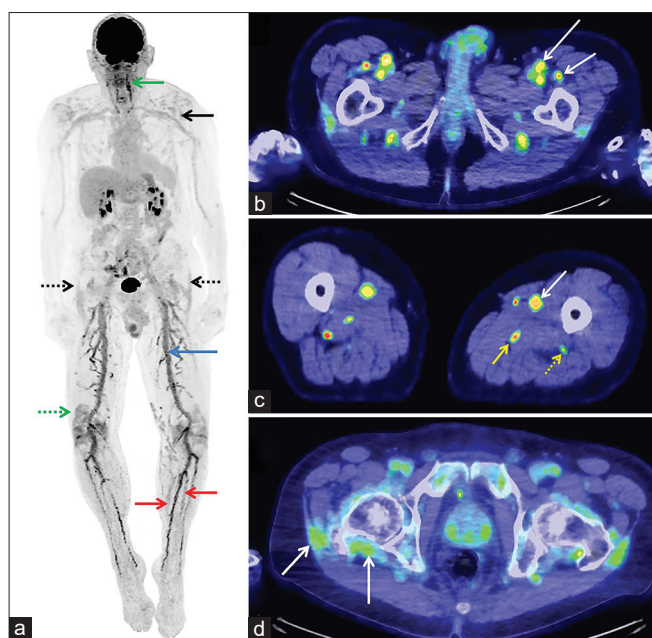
Whole-body maximum intensity projection image (a) shows fluorodeoxyglucose uptake in both iliofemoral (blue arrow) and tibioperoneal (red arrows) and vertebral (green arrow) arteries. Subclavian and axillary arteries show fluorodeoxyglucose uptake less than the liver (black arrow). There is fluorodeoxyglucose-avid synovitis (dotted green arrow) and periarticular uptake (dotted black arrows) suggestive of polymyalgia rheumatica. Axial-fused positron emission tomography/computed tomography images show increased fluorodeoxyglucose uptake in femoral (white arrows, b), anterior tibial (white arrow, c), posterior tibial (solid yellow arrow, c), and peroneal (dotted yellow arrow, c) arteries and periarticular and synovial uptake in hip joints (white arrow, d)
